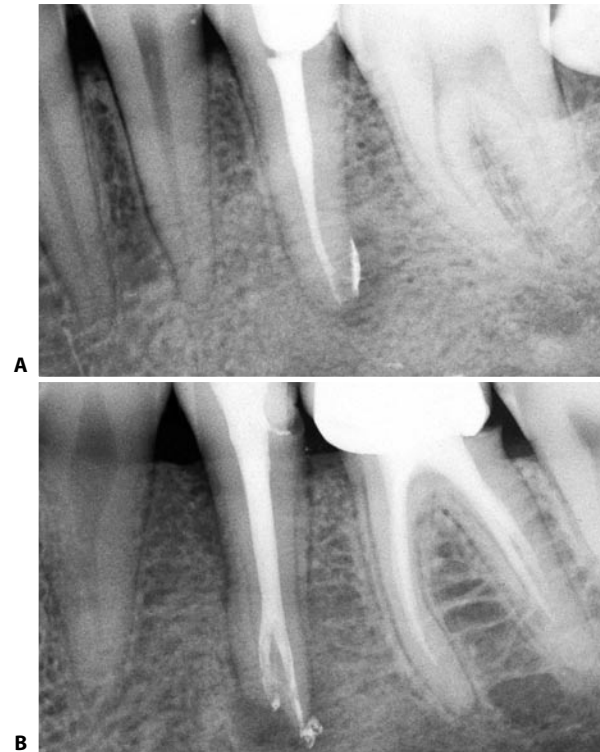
A. Postoperative radiograph of a lower second premolar with a single canal. B. Postoperative radiograph of a lower second premolar with a canal that bifurcates near the apex.
